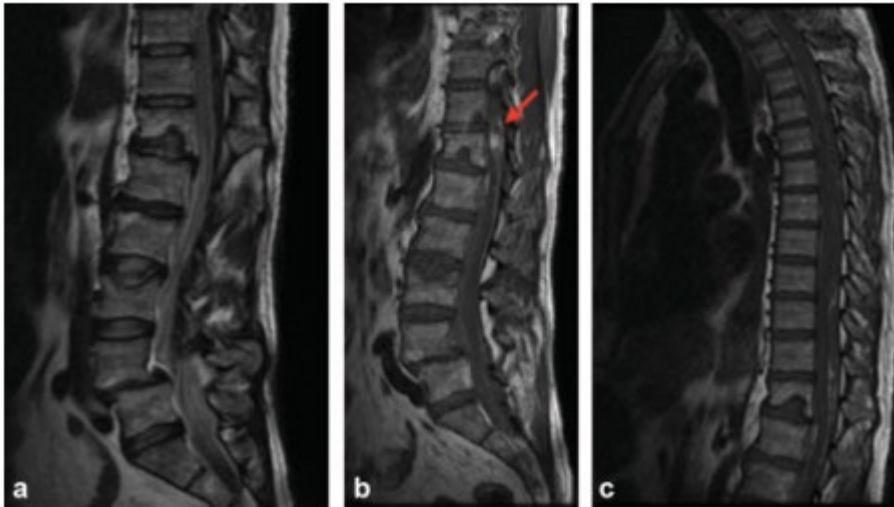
(a–c) Magnetic resonance imaging performed on admission documented a hyperintense lesion in the T1-weighted sequence, with an oval component (red arrow) at T12 level and spinal cord compression.
